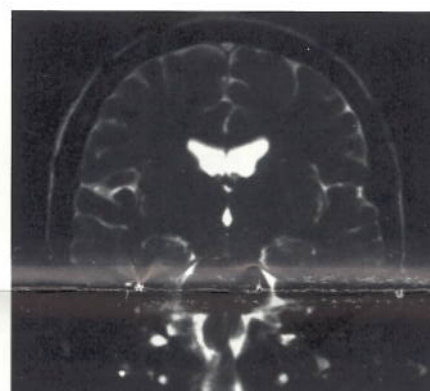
TrueFisp sequence for fast T2-weighted imaging.
